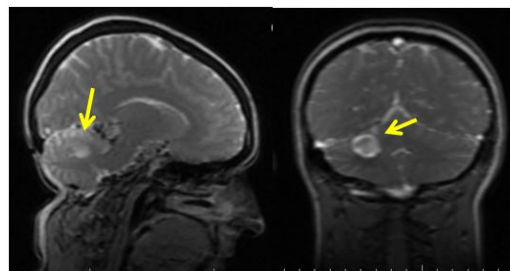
Maternal cranial MRI 6 months' post tumor resection
